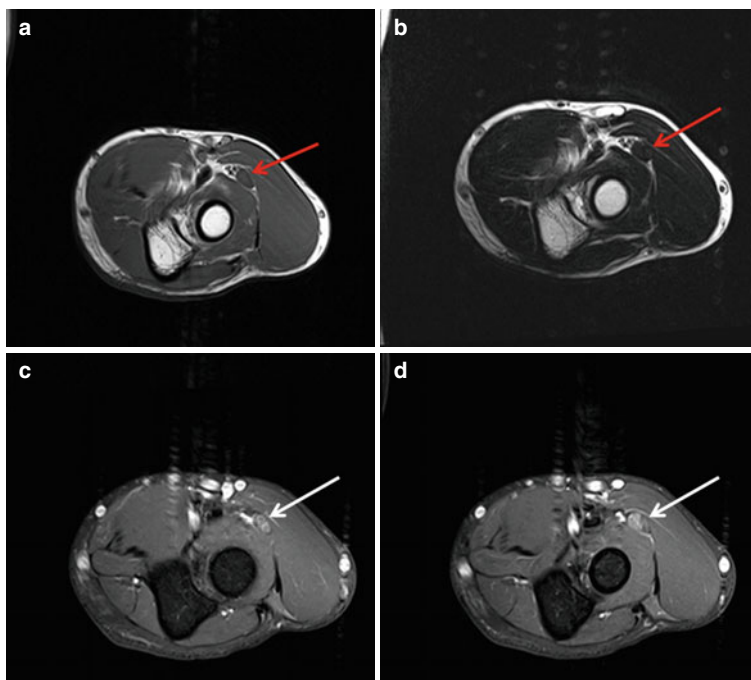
MRI left elbow – T1w (a), T2w (b) and T1 post-gadolinium (c, d). A 10 mm, nodular, minimally enhancing mass is seen to arise from the left posterior interosseous nerve (white arrow), just distal to the radiocapitellar joint, as it courses between the brachioradialis and the supinator. The mass appears homogenous and hypointense on T1 and T2 weighted images (red arrow)
